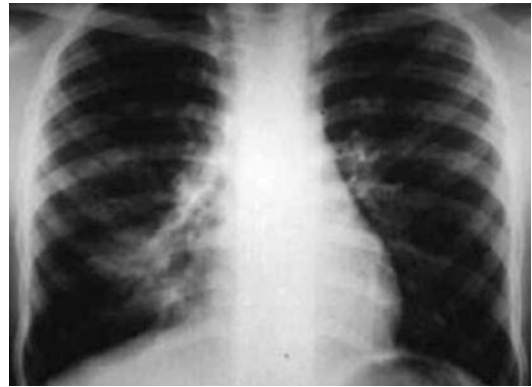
Interstitial-alveolar pneumonia. Chest X-ray of 9-year-old schoolchild shows a right lower lobe interstitial-alveolar image
